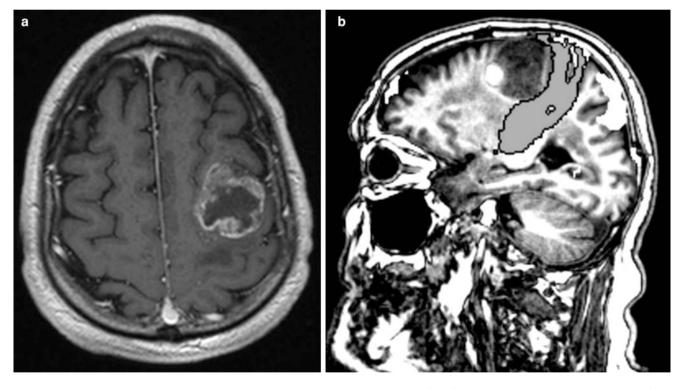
Preoperative axial postcontrast T1-weighted magnetic resonance imaging (a) and sagittal tractography imaging (b) in a 77-year-old man with a left Rolandic glioblastoma. There was a close contact
